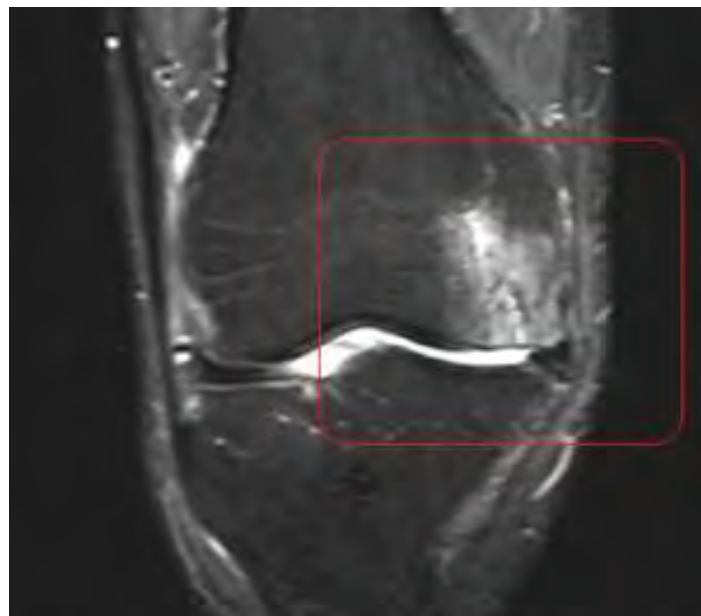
MRI imaging of spontaneous osteonecrosis of the knee (SONK) showing bone marrow edema and flattening of the medial femoral condyle. (Case courtesy of Dr Fazel Rahman Faizi, Radiopaedia.org, rID: 66265)
